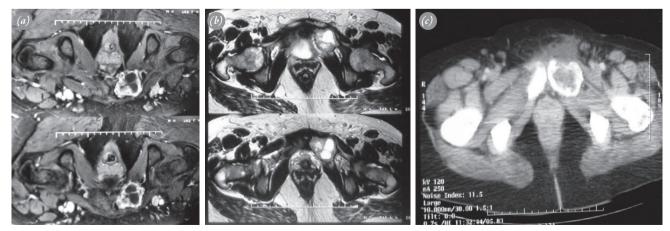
(a) Magnetic resonance imaging showed a well-defined expansile bone lesion which was hypointense in T1-weighed images, with heterogeneous uptake of contrast material. (b) Magnetic resonance imaging showed a well-defined expansile bone lesion which was hyperintense in T2-weighed images, with heterogeneous uptake of contrast material. (c) Magnetic resonance imaging demonstrated cystic cavities and nodularity in sagittal FS-T1-weighted image.
